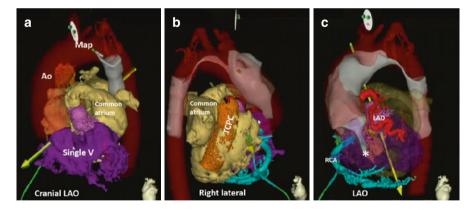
Real-time visualization of the mapping catheter (Map) during retrograde approach using remote magnetic navigation. Fast anatomical mapping (FAM, *in grey in the picture*) of the aorta allows merging and superimposition of 3D pre-acquired (from CT or MR scan) reconstructions with the contact map in a stepwise fashion in order to guide the operator during the procedure. Please note the distance of the FAM to the aorta (Ao) descending in a, which is adapted in b and c to fit the full aortic arch. The *yellow arrow* depicts the direction of the magnetic field that the magnetic Map catheter will align parallel to, thereby allowing remote navigation of the catheter tip. The forward and backward motion is a mechanical motion via the CardioDrive (Stereotaxis Inc.). Note that the catheter has just passed the open aortic valve in panel c (asterisk)
